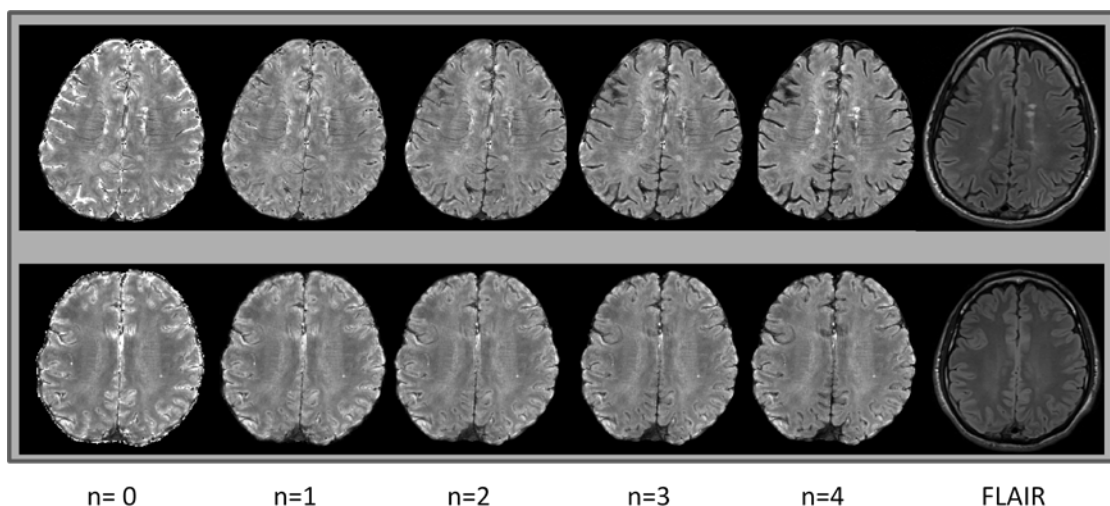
Example of the $FST2^*$ images (obtained using Eq. [4.9] with different parameter n), and corresponding FLAIR $T2$ images. Top row – images from a subject with relapsing remitting MS, bottom row - images from a healthy subject.
